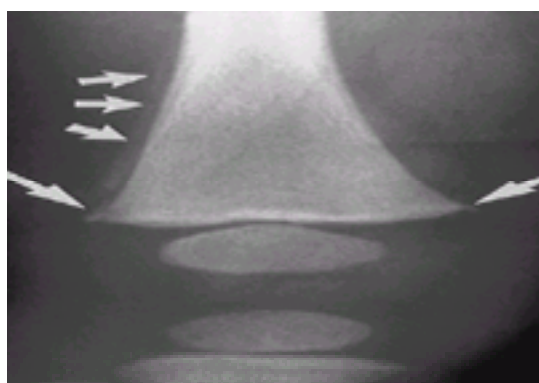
Radiograph of the right knee of a 3½-month-old victim of child abuse. The metaphyseal corner fractures (*large arrows*) are considered diagnostic of abuse. Also evident is periosteal new bone formation (*small arrows*), proof of a significant delay between injury and medical evaluation.
